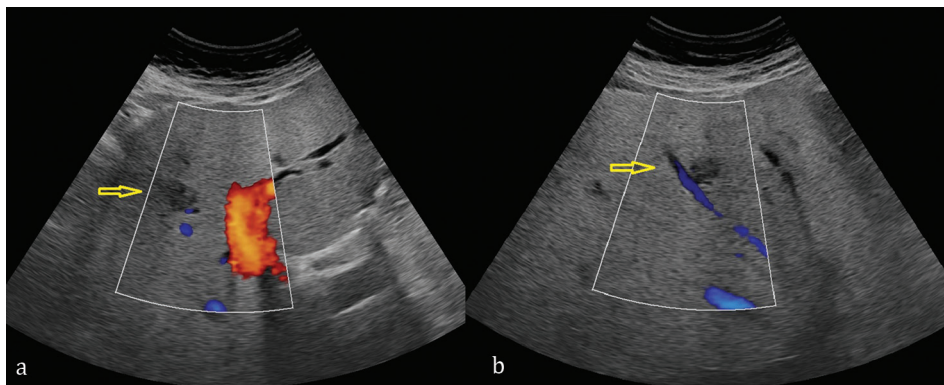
Liver Gaucheroma: a) ultrasound findings: multiple hypo echoic small focal lesion, without mass effect on surrounding vessels.
